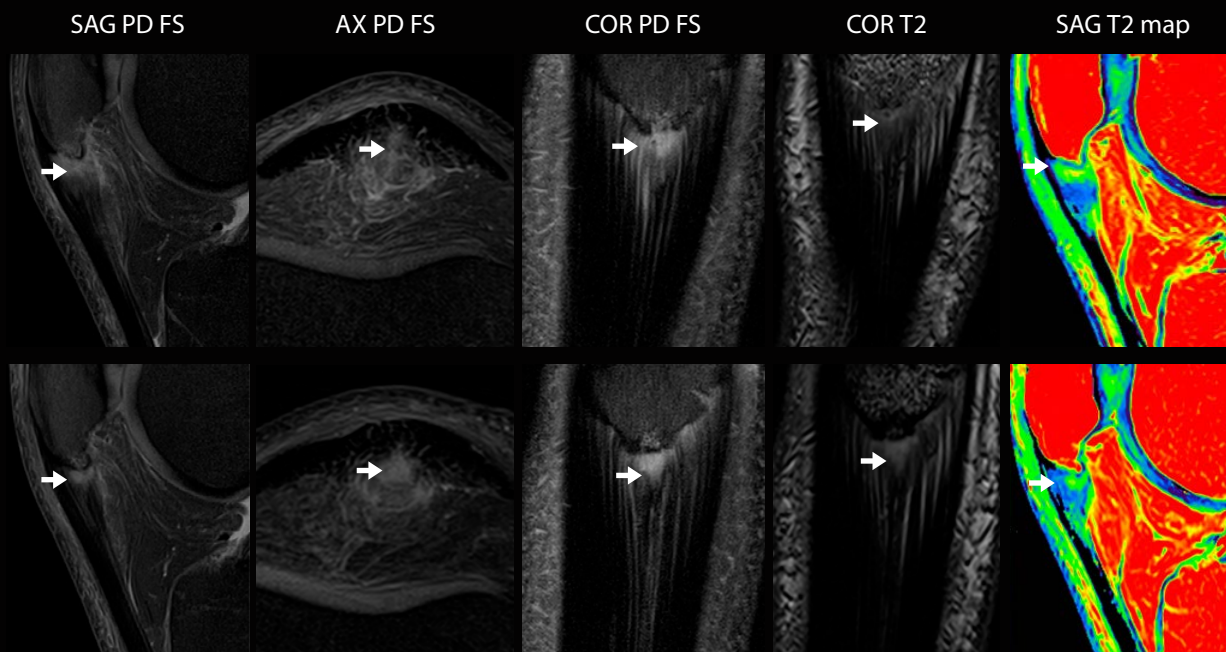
Magnetic resonance imaging protocol showing the evolution of patellar tendinopathy from baseline (upper row) to 6-month follow-up (lower row) in a participant that underwent a treatment with BM-MSC. White arrows indicate the area of the injury. Less edema and thinner tendon are observed after treatment, with a reduction of the inflammatory area and the presence of reparative tissue in the follow-up.
